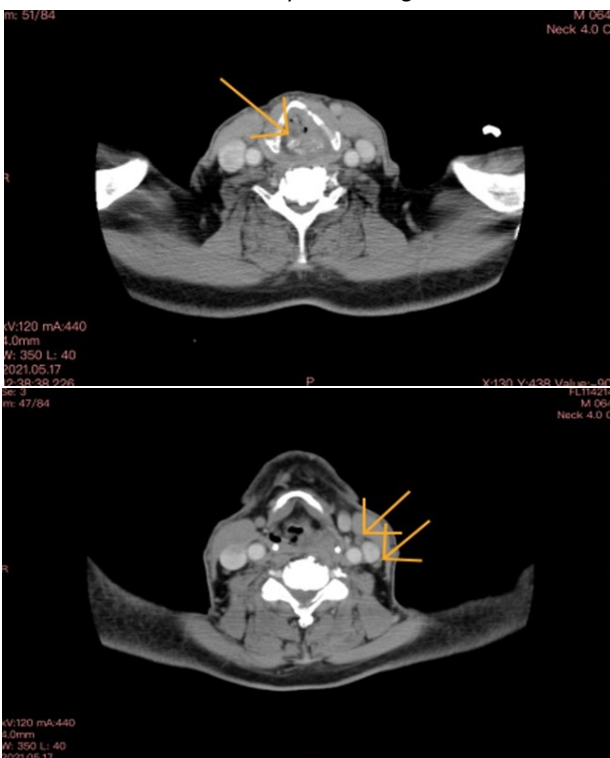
Case 3: A 64-year-old male patient presented with voice hoarseness, neck pain, and swelling. CT showed definite cartilage invasion; however, it was confirmed that the lymph nodes were involved.
